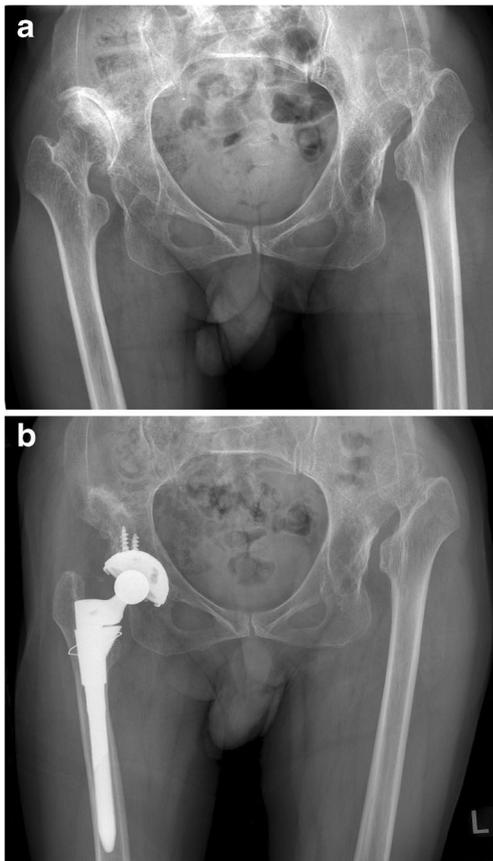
a) Pre-operative radiography. b) Post-operative radiography. Amount of lengthening, 3.54 cm. Femoral shaft length, 36.1 cm. L/F ratio = 9.8
